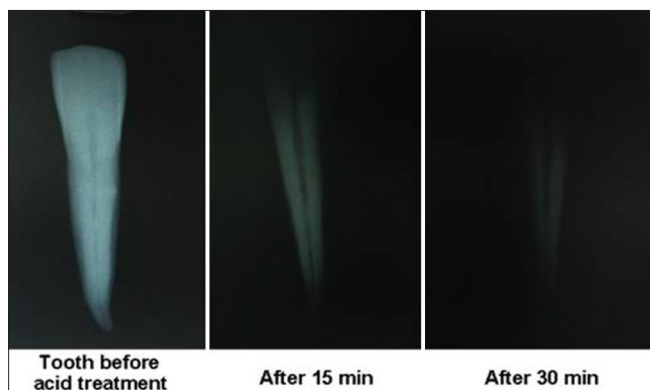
Radiographical appearance of teeth treated with conc. HCl at different interval
